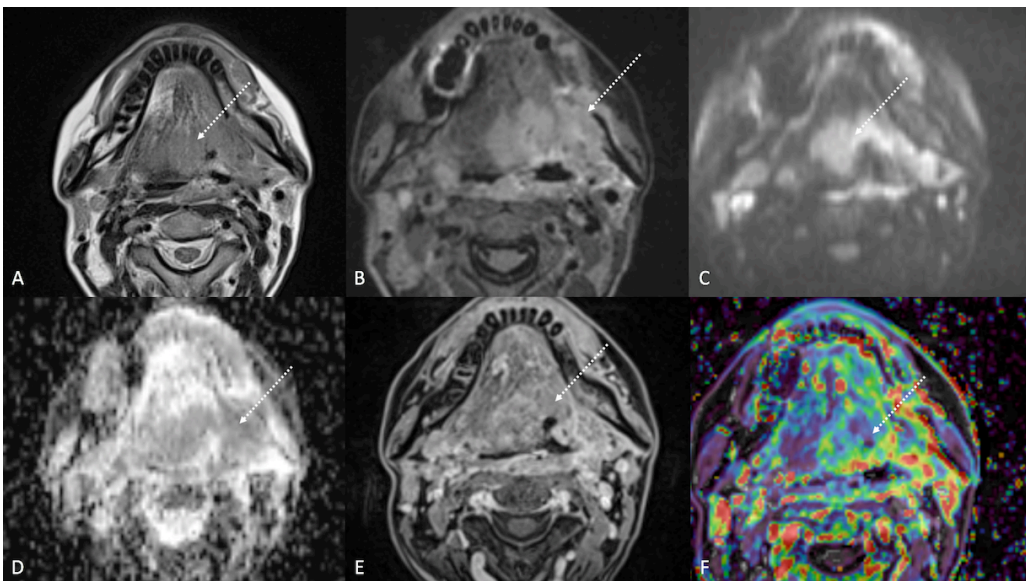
Same patient as Figure 5. Post-treatment Magnetic Resonance Imaging (MRI) shows post-radiochemotherapy (CRT) inflammatory changes in a 36-year-old female patient affected by nasopharyngeal carcinoma with tumoral extension to bilateral Ronsemüller fossa, left nasal choana, and middle skull base, and left lymph node metastasis (T3N3). Post CRT inflammatory tissue (with the striped arrows) shows hyperintense signal on T2-weighted (a), T2-weighted fat saturated (b), and diffusion weighted  $b_{800}$  images due to «T2 shine-through» effect (c), and high median apparent diffusion coefficient value ( $1.534 \times 10^{-3} \text{ mm}^2/\text{s}$ ) (d). After gadolinium contrast agent injection, post-CRT inflammatory tissue shows submucosal enhancement of 5 mm-thickness (e), and very high  $K(\text{trans})$  value ( $595,25 \times 10^{-3} \text{ min}$ ) on dynamic contrast enhancement-perfusion weighted imaging (f). Ratio between  $K(\text{trans})$  values of the primitive tumour and of the residual tissue after CRT, standardized with respect to  $K(\text{trans})$  value of the ipsilateral trapezius ( $K(\text{trans})_{\text{post/pre/muscle}}$ ), was 3.171. These results suggest an increase in capillary permeability caused by CRT.
